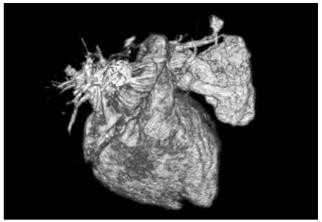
Three-dimensional computed tomography of the chest detected the presence of an arteriovenous malformation.
